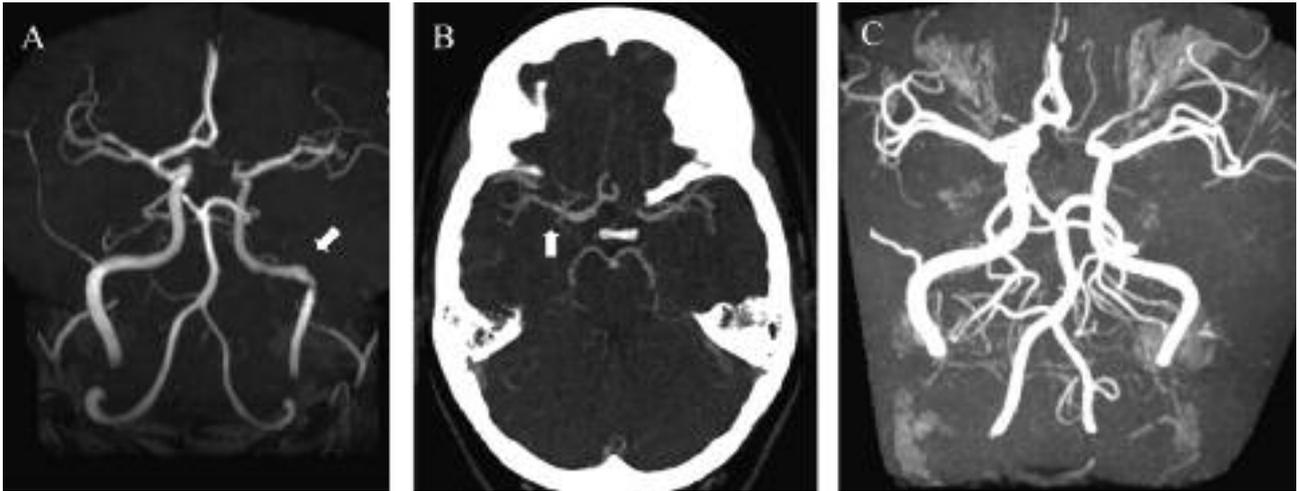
3D time-of-flight MRA demonstrating irregular configuration of left petrous segment dICA (arrow, A) on the day of admission. CTA showing short-segment stenosis of the right MCA main stem one day later (arrow, B). MRA without any vascular changes at 6-month follow-up (C).
